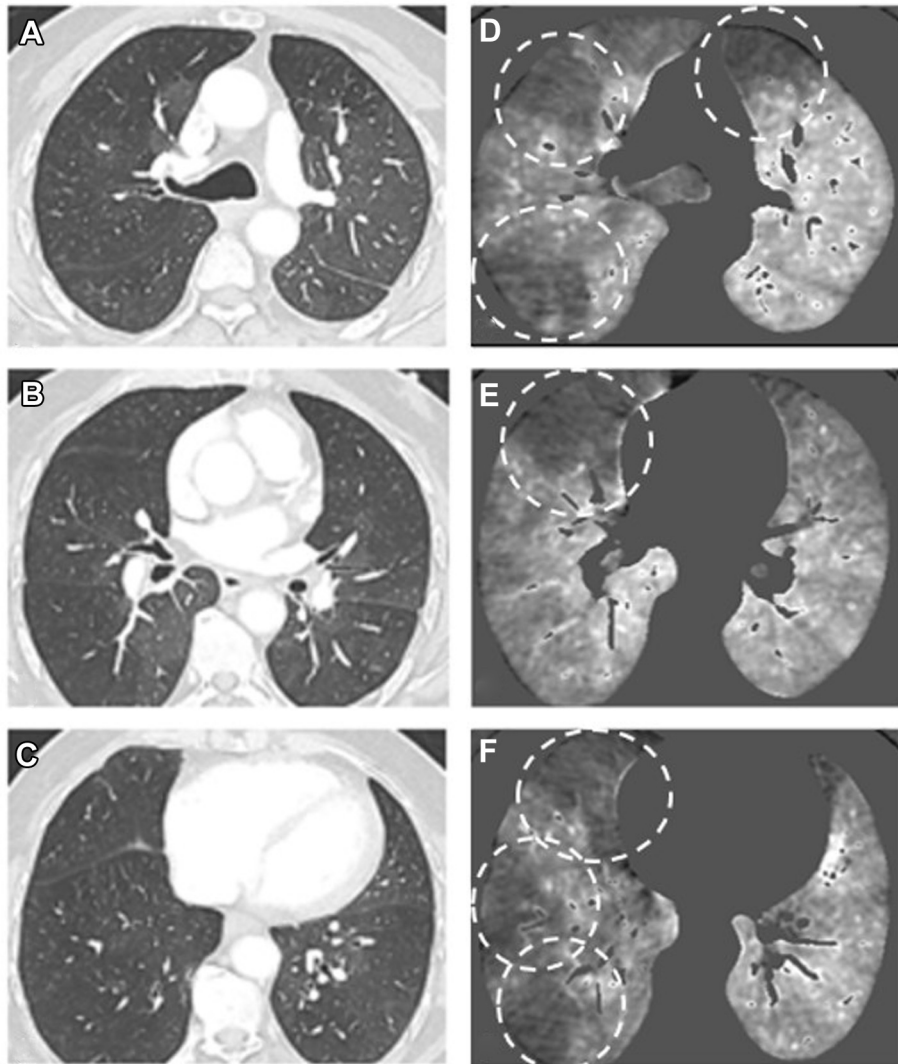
Morphologic and perfusion images generated from the same dual-energy CT scan acquisition of a patient with chronic thromboembolic pulmonary hypertension. Mosaic perfusion on lung images with CT features of peripheral chronic pulmonary embolism depictable in the right lower lobe (A, B, C). Corresponding perfusion images showing numerous triangular perfusion defects in both lungs, more important on the right side (white circles in D, E, F).
